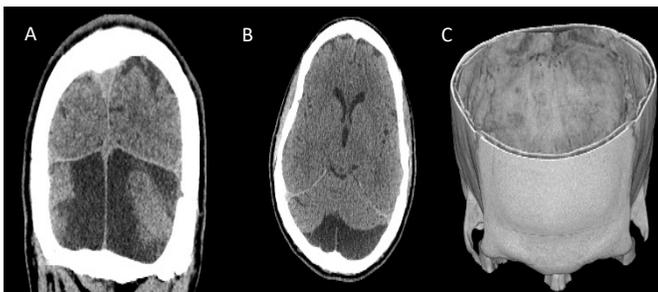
(A) Coronal and (B) Axial pre-op CT. (C) 3D representation of calvarium restructuring.
